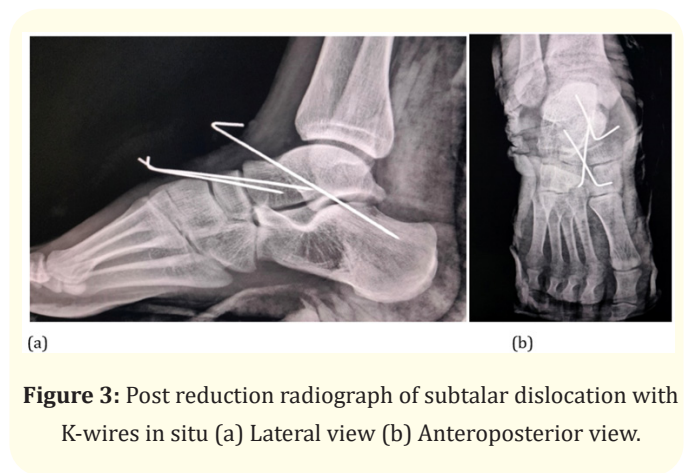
Post reduction radiograph of subtalar dislocation with K-wires in situ (a) Lateral view (b) Anteroposterior view.
